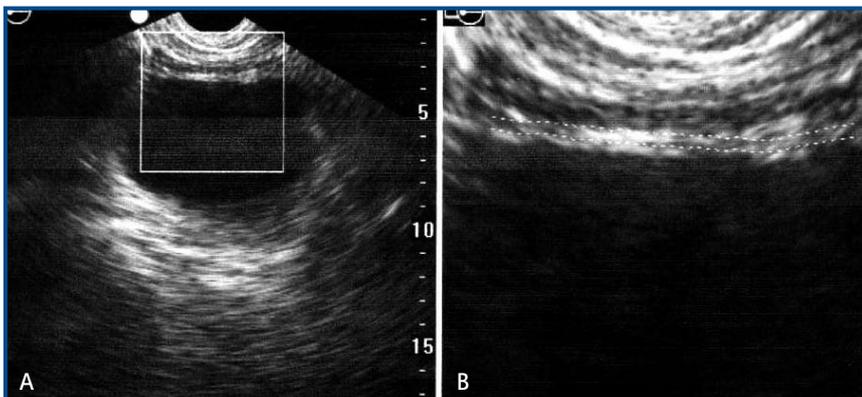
Ultrasonographic image of the bladder (A) and close-up of the bladder wall (B). The BladderScan® BVM 6500 device (Diagnostic Ultrasound Corporation, Bothell, WA) accurately locates the bladder wall and analyzes the wall thickness.
